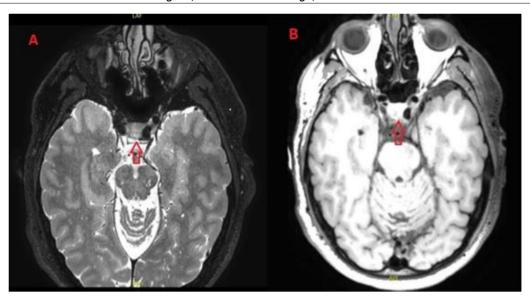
The red arrow points to a lesion on the dorsal surface of the clivus. The lesion is hypointense without contrast uptake on T1-weighted sequences (A), and hyperintense on T2-weighted sequences (B). ff
